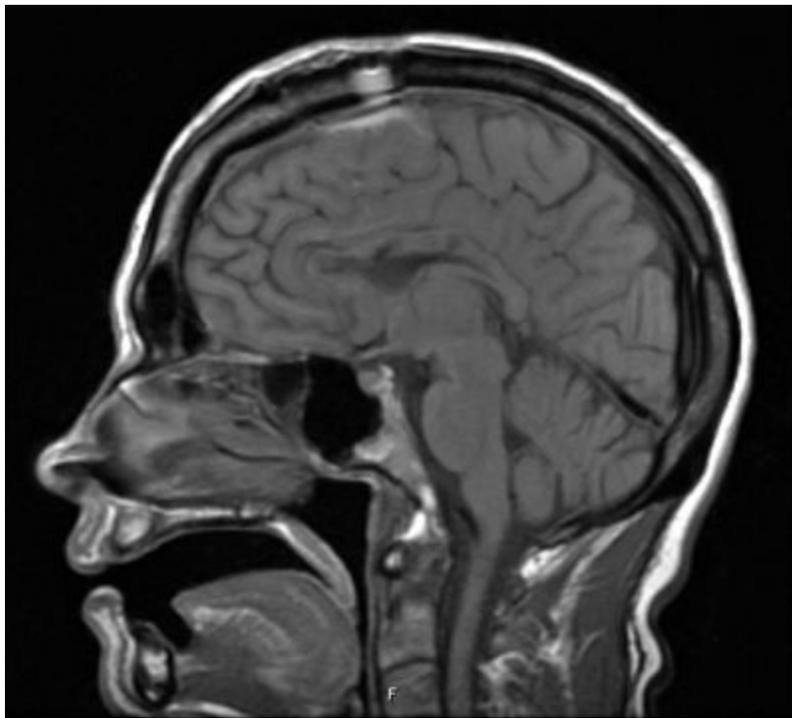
Sagittal T1 magnetic resonance image showing an anterior two-thirds callosotomy.
